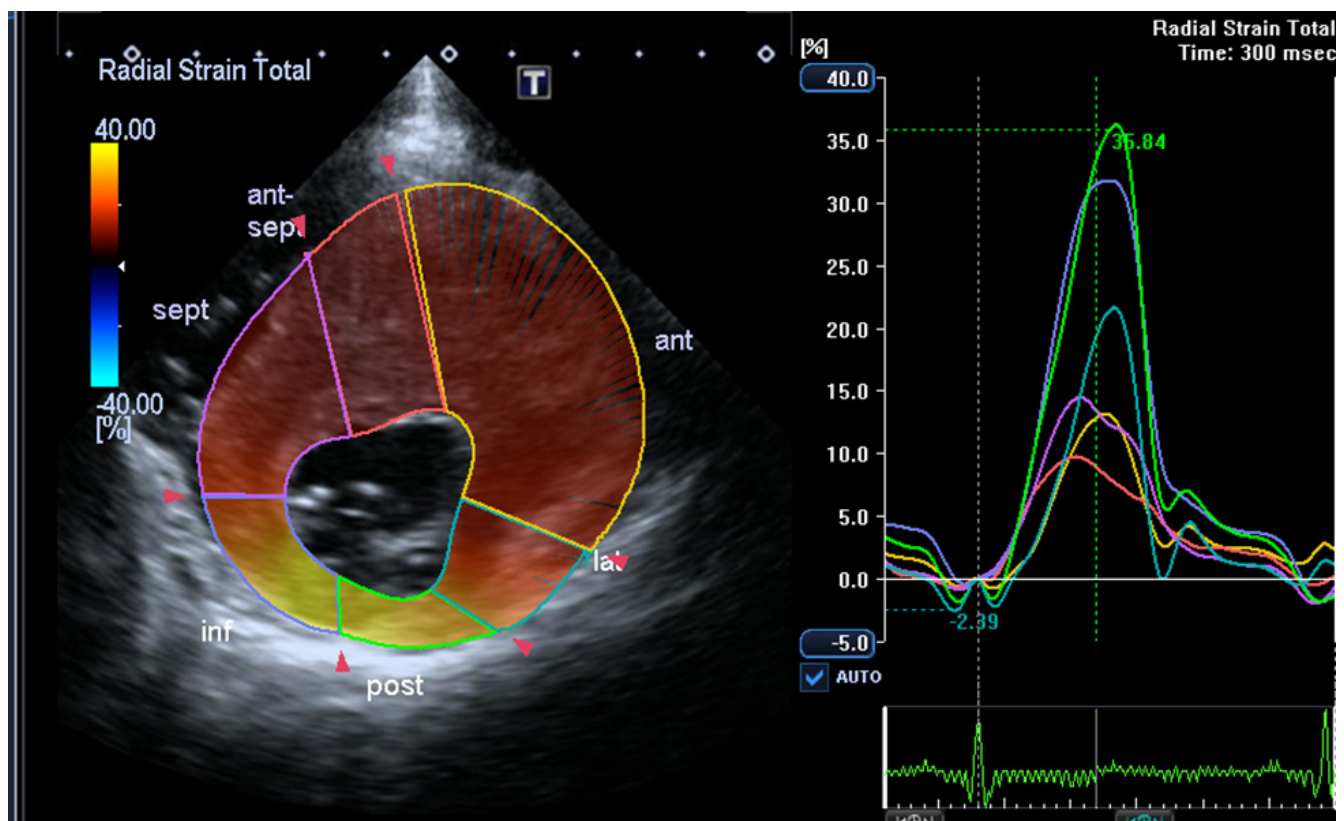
Measurement of left ventricular radial strain in 2D speckle tracking mode. Parasternal position along the short axis of the left ventricle in the papillary muscle level of the mitral valve.
